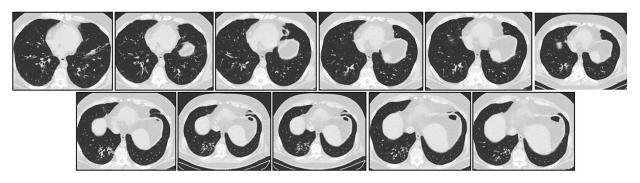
Lung Disease CT-Scans
